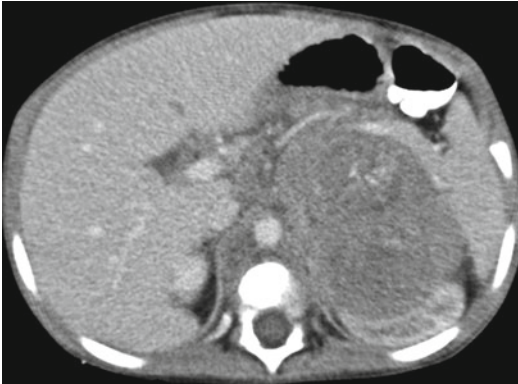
Neuroblastoma – *CT*. Contrast-enhanced axial CT images in an 18-month-old boy with an adrenal gland origin neuroblastoma compressing and displacing the adjacent kidney
